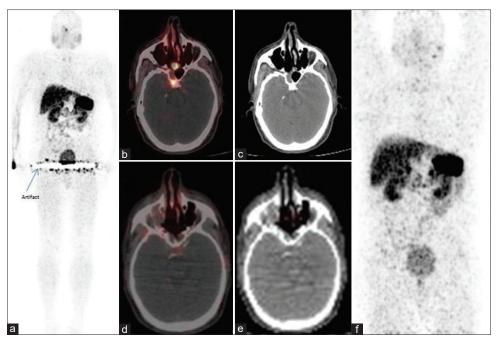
Ga 68 DOTATATE positron emission tomography/computed tomography maximum intensity projection image (a) and fused axial image (b) and computed tomography (c) images showing focal radiotracer uptake just anterior to sphenoid ostium on the right paramedian side, maximum standard uptake value 8.40 with no obvious morphologic lesion suspicious of residual disease. Postresurgery and adjuvant radiotherapy Maximum intensity projection image (f) and fused axial image (d) and computed tomography (e) images showing no abnormal tracer accumulation.
